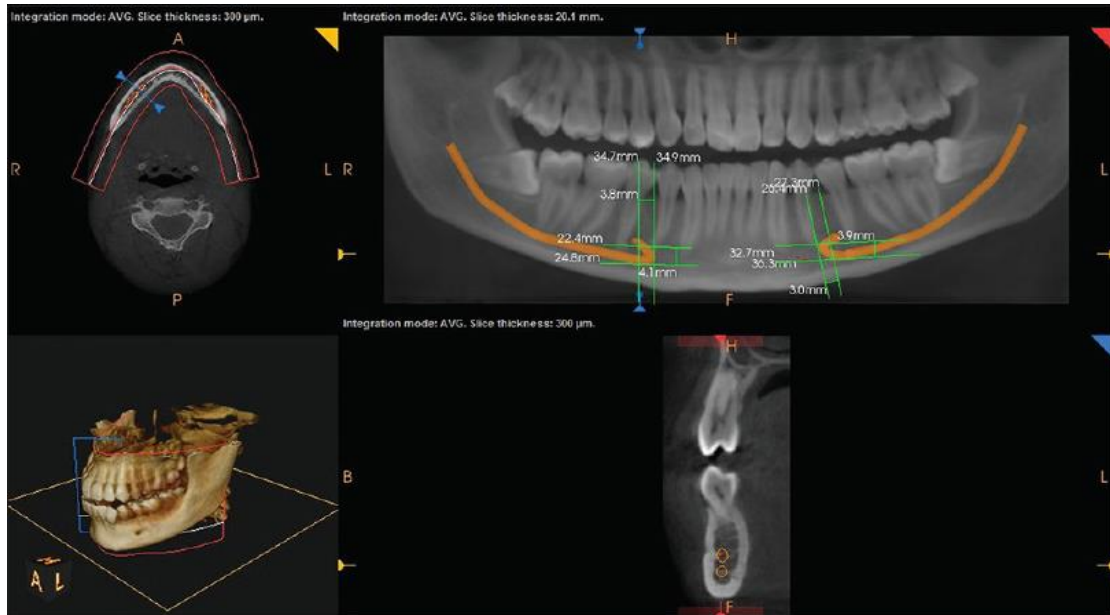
Anterior loop in CBCT showing three linear measurements with 3D reconstruction.
